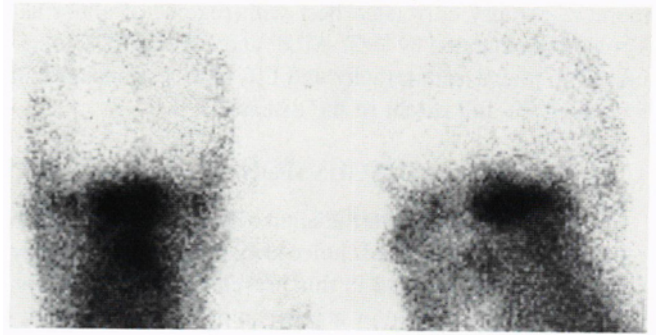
Planar skull scintigrams revealing increased uptake of ^{67}Ga in the regions of skull base (anterior, left lateral).
